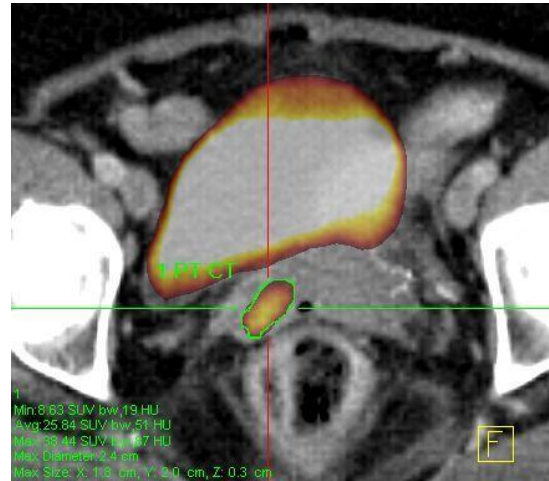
Axial fused PET/CT image shows an avid FDG-avid lesion (SUV_{max}: 38.44) in the right anterior vaginal fornix (hairline).
